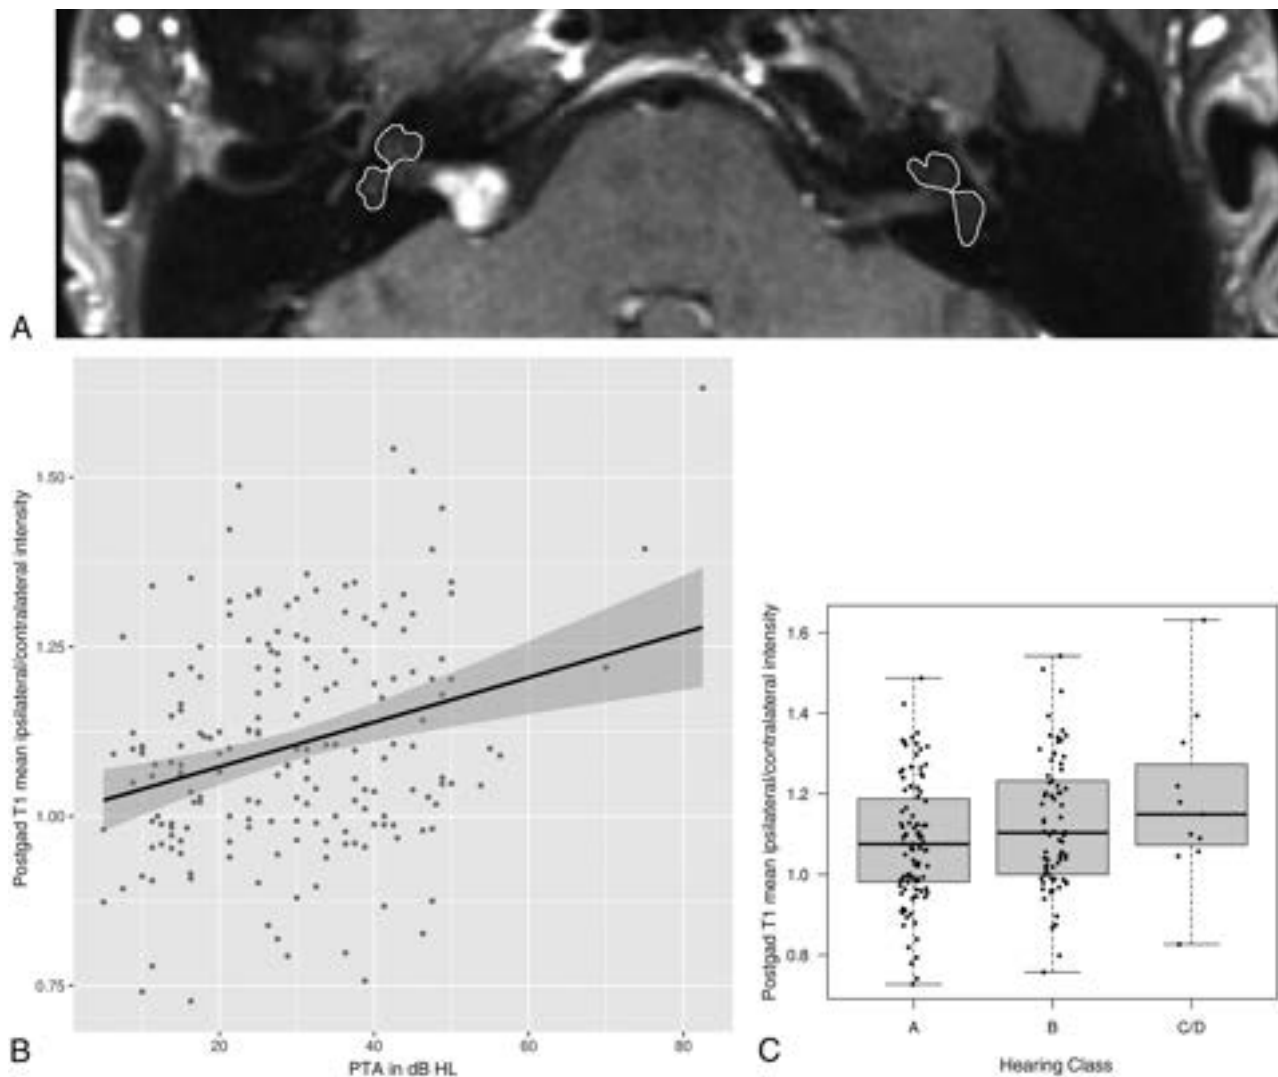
Postgadolinium T1 signal intensity and hearing impairment. A, Representative axial postgadolinium T1 MR imaging and ROIs used for analysis. Increased PTA (B) and worse AAO-HNS hearing classification grades (C) are associated with increased relative signal intensity. HL indicates hearing loss; postgad, postgadolinium.
